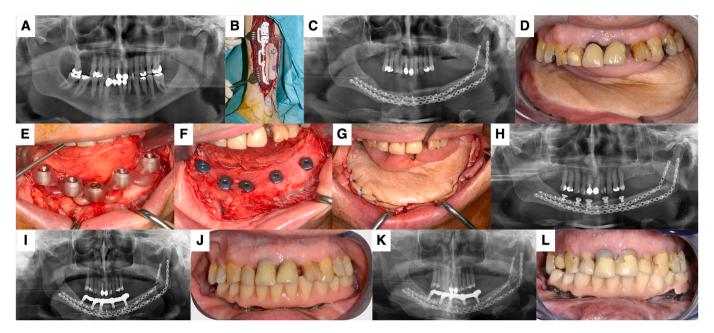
Representative case of mandibular fibula flap. A) Preoperative radiograph depicting squamous cell carcinoma in the left mandible with osseous infiltration. B) Harvesting the fibula flap. C-D) Radiograph and intraoral photo depicting bony and soft tissue reconstruction of the mandible. E-F) Guided placement of five 4.0×5.0 mm implants and thin crestal temporary abutments. G) Refixed skin flap covering the implants. H) Postoperative panoramic radiographs depicting covered implants. I-J) Panoramic radiograph and intraoral photo depicting cemented prosthesis with metal framework on the day of insertion. K-L) Panoramic radiograph and intraoral photo taken four years after prosthesis insertion.
